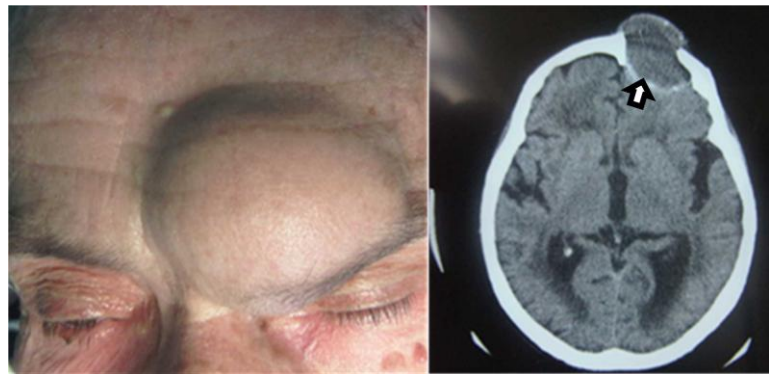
CT image of osteoma in the skull with bone destruction
